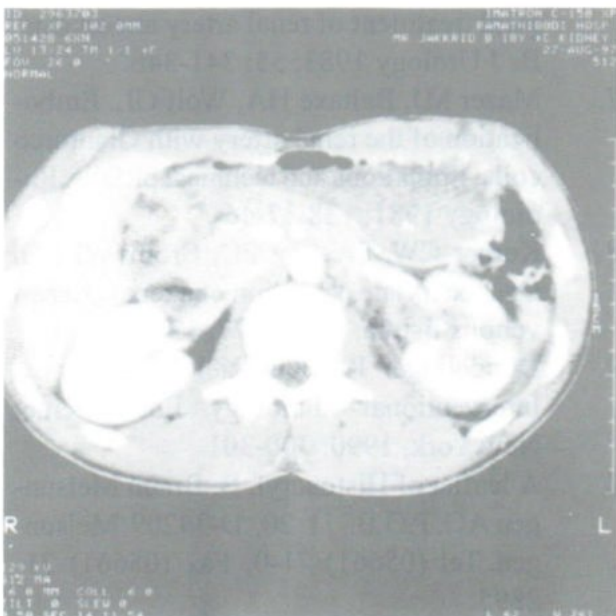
Follow up CT scan two weeks later showed the disappearance of both fistula and the pseudoaneurysm; good excretory function of left kidney was observed.
